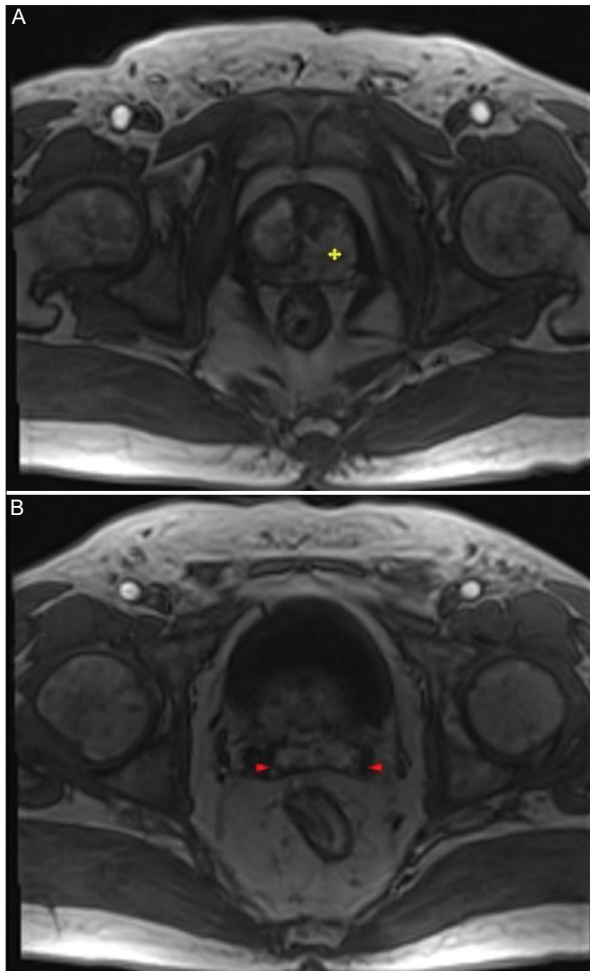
A and B: post-contrast T1-weighted image of the same patient without fat suppression. A: the lesion has heterogeneous contrast (yellow mark). B: seminal vesicle invasion is seen as a contrast-enhancing space-occupying formation (between the red arrowheads).
